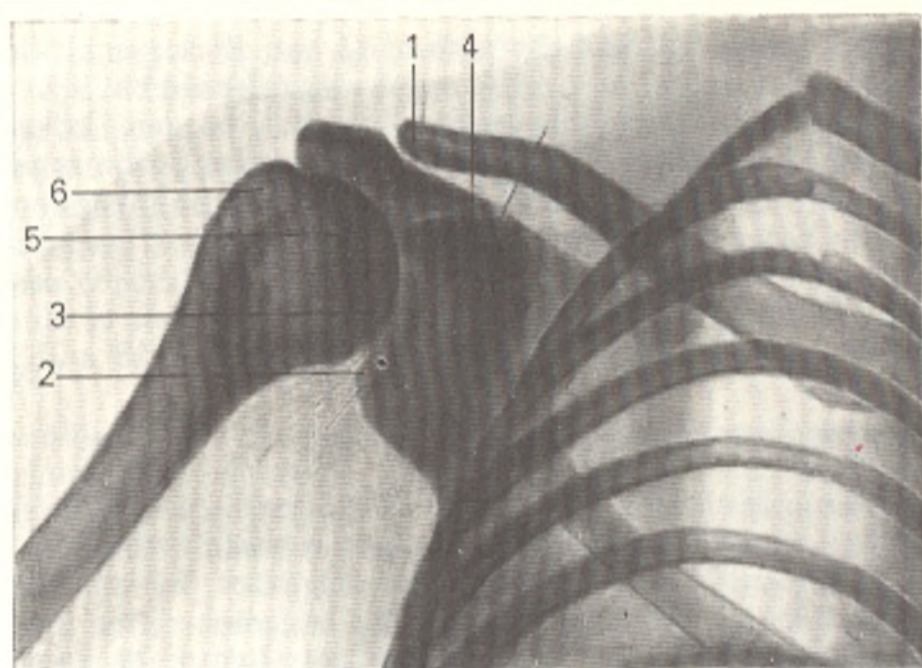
Radiograph of the shoulder joint.
